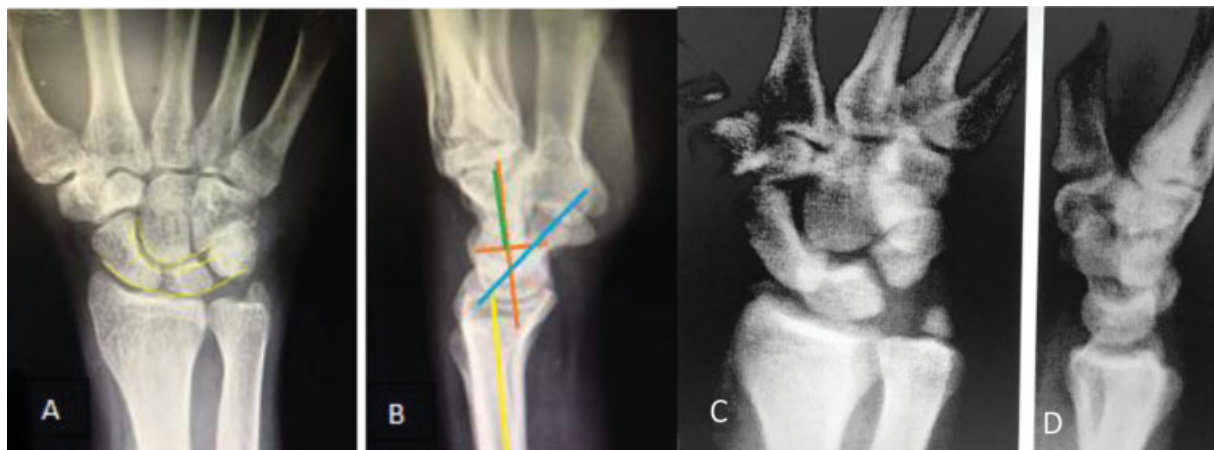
(A) Gilula arches and (B) axes of the carpal bones with the radius (necessary for measuring misalignments and dislocations). (C and D) Posteroanterior (PA) and lateral radiographs of a perilunar fracture-dislocation, with involvement of radial and ulnar styloid. Note the broken arches and loss of normal angulations.
